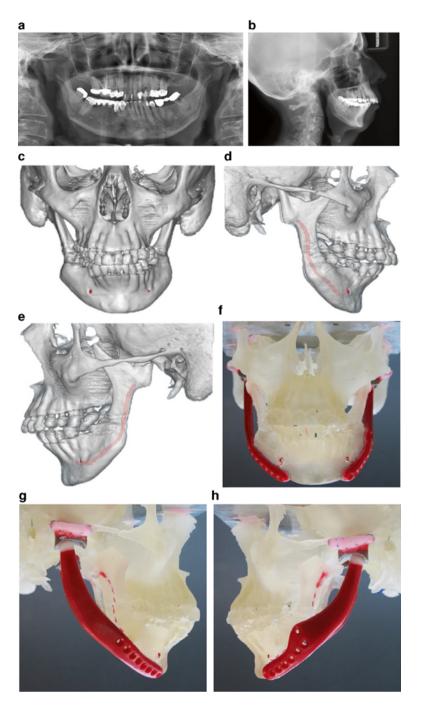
Case #1 immediate primary TMJ TJR reconstruction. (a) Preoperative panoramic x-ray; note the severe resorption of the mandibular angles as well as condyles. (b) Preoperative lateral cephalometric x-ray showing severe resorption of the mandibular angles, mandibular retrognathia, and microgenia. (c-e) Preoperative 3D renderings corroborating the findings of the plain films. (f-h) Prosthesis wax-up. (i-k) Actual total TMJ custom-made prosthesis. (l) Left and (m) right intraoperative endoscopic views of the mandibular alloplastic components in the planned location. (n) Before and after patient's profile. (o) Postoperative CT scan 3D, (p), panoramic, (q), lateral, and (r) anteroposterior cephalometric radiographs showing good prosthesis placement
